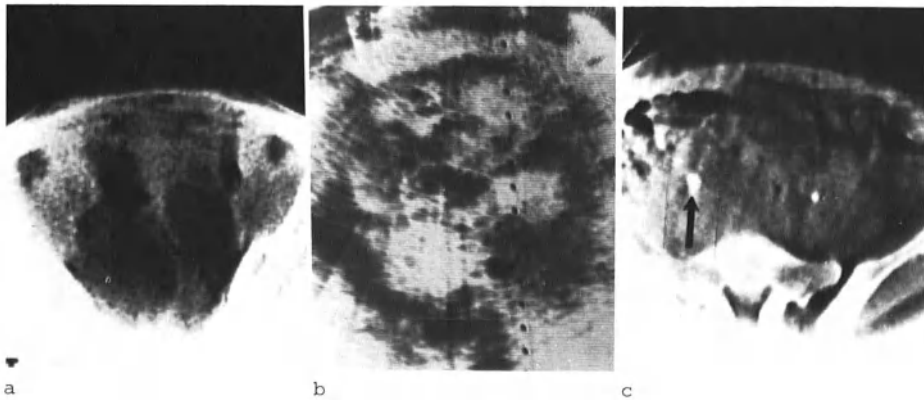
Ovarian carcinoma. (a) Soft tissue mass is seen involving entire pelvis on a section 5 cm cephalad to the symphysis. Both cystic and solid components are seen. Bowel is intimately related to mass. (b) Transverse ultrasound at same level also reveals complex nature of mass. At surgery, massive bilateral cystadenocarcinoma of ovaries was found which was unresectable. (c) C.A.T. section 8 cm cephalad to the symphysis demonstrates right hydroureter (*arrow*). Tumour mass extended cephalad at least 3 more centimetres
